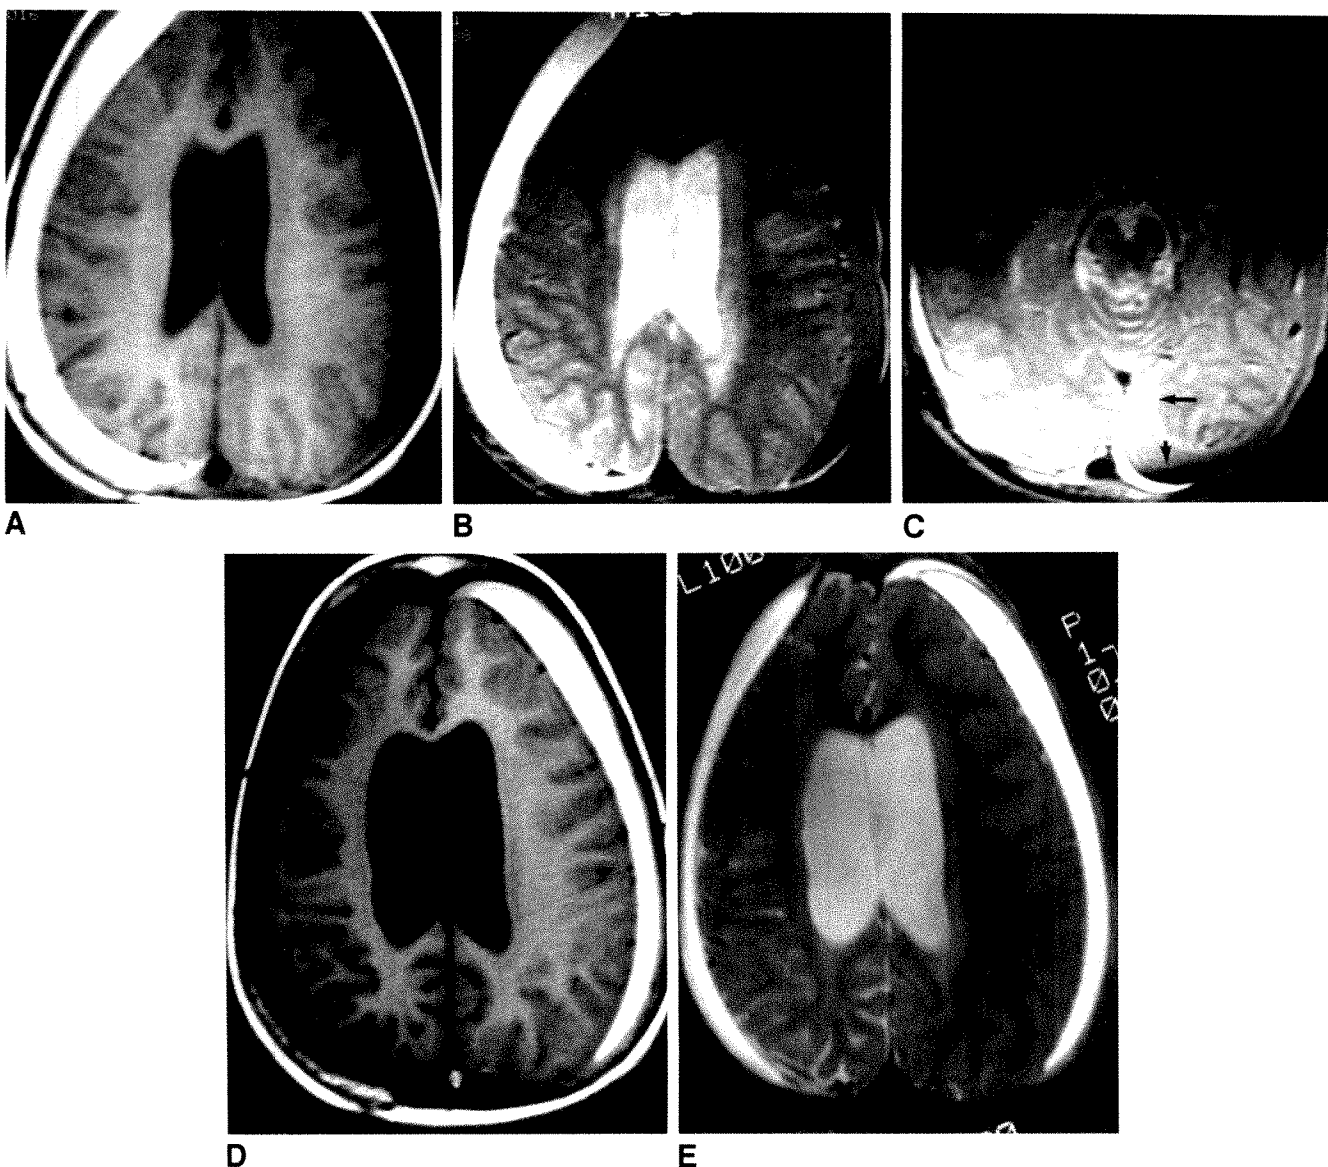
Case 21: routine follow-up scan in patient with known chronic SDH of 8 months duration after shunting for a tectal glioma shows acute rehemorrhage on the left and a right-sided subacute rehemorrhage. Although clinically asymptomatic, this bleeding into preexisting chronic subdural collections was new compared with prior CT scans.
